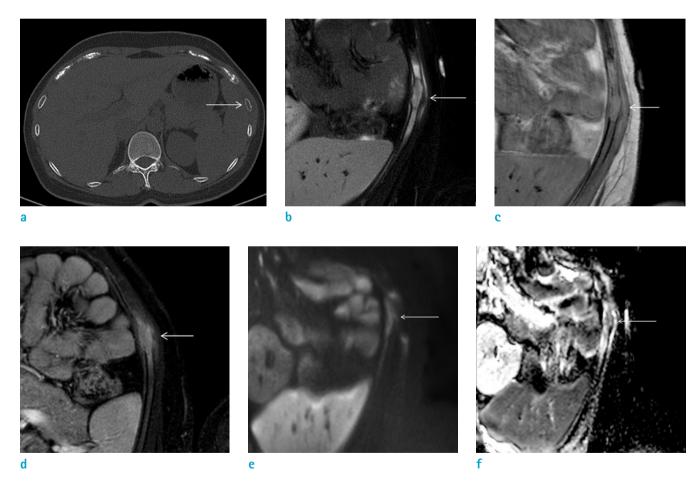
Forty-year-old female patient with LCH on the left 8th rib. (a) Axial CT image of the chest shows an expansile osteolytic lesion (arrow) with cortical thinning and disruption at the left 8th rib. (b) Axial T2-weighted image with fat saturation shows an intramedullary high-signal intensity mass (arrow) with surrounding soft tissue edema. (c) Axial T1-weighted image shows a low-signal intensity mass (arrow). (d) Axial T1-weighted image with fat suppression after gadolinium administration shows infiltrative enhancement (arrow). Diffusion restrictionis not clearly visible on the (e) axial diffusion-weighted image (DWI) and (f) axial apparent diffusion coefficient map (ADC map) (arrows).
